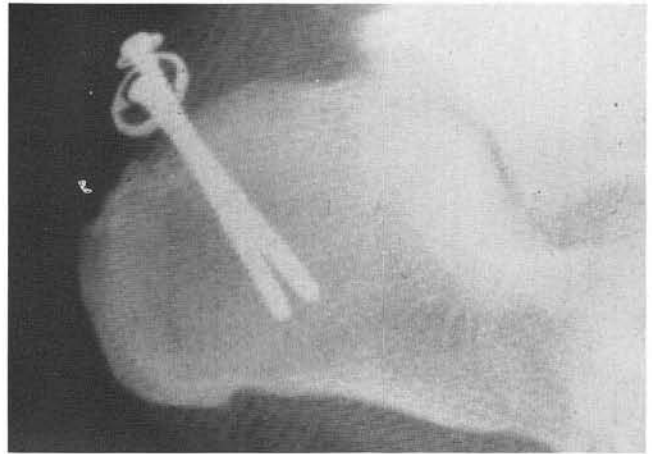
Radiograph of an attempted reinsertion of the tendo Achillis with screw fixation. Care must be taken to monitor the prominence of the screw head and any washer system that may be used on the posterior aspect of the calcaneus to prevent shoe irritation and skin break-down. The size of the screw head and any washer system can be detrimental to the postoperative result.
